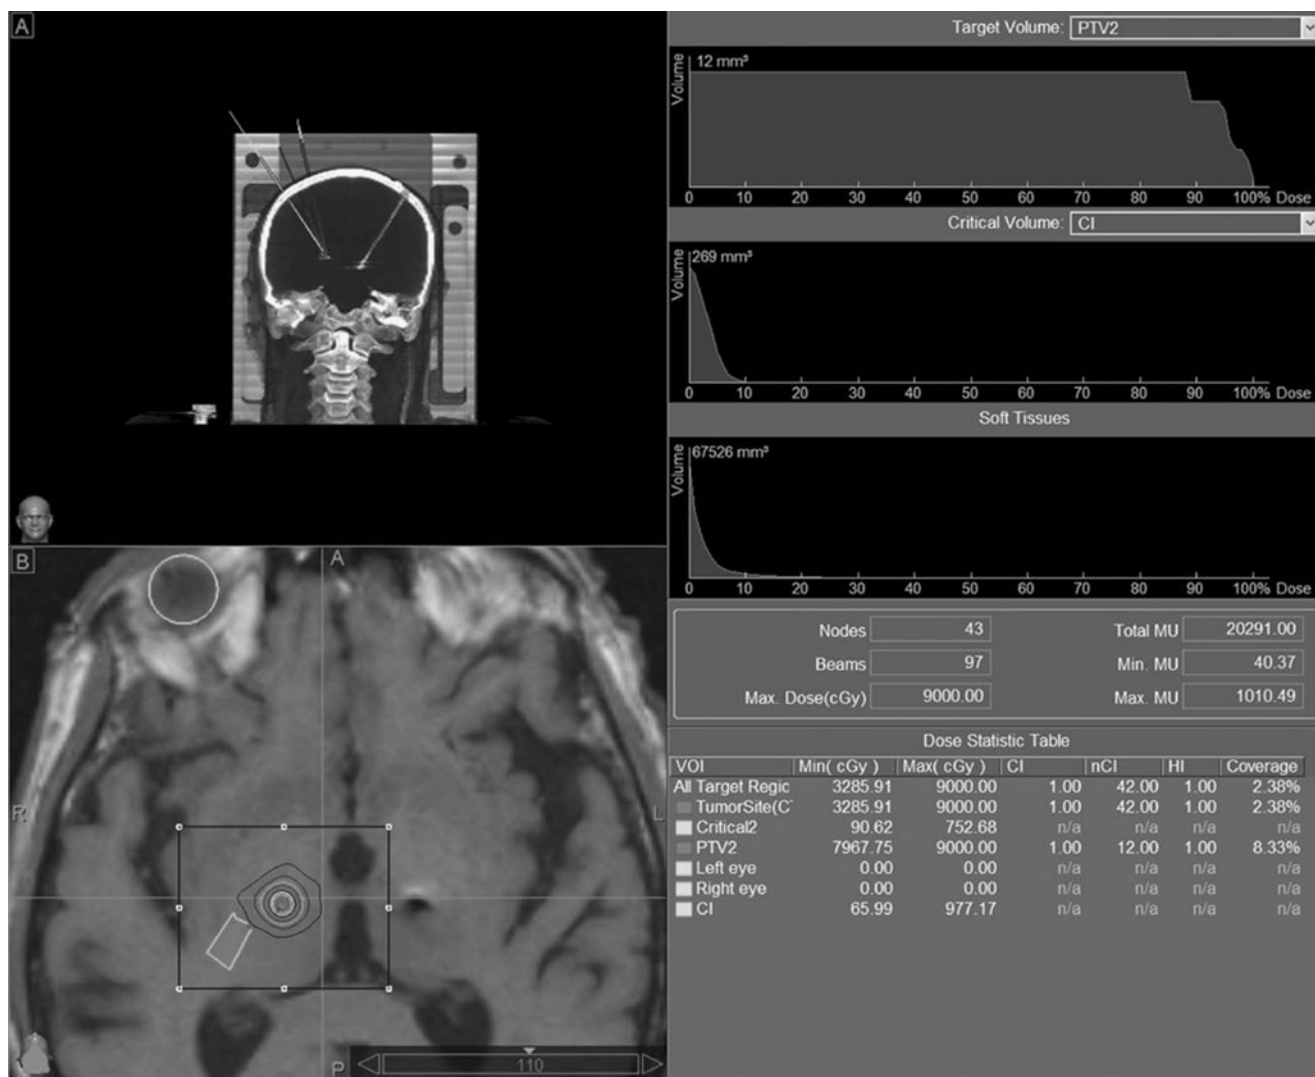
Patient's MRI merged with the planned treatment. The 18-month post-treatment MRI shows a lesion surrounded by oedema overlapping the 10% isodose line
